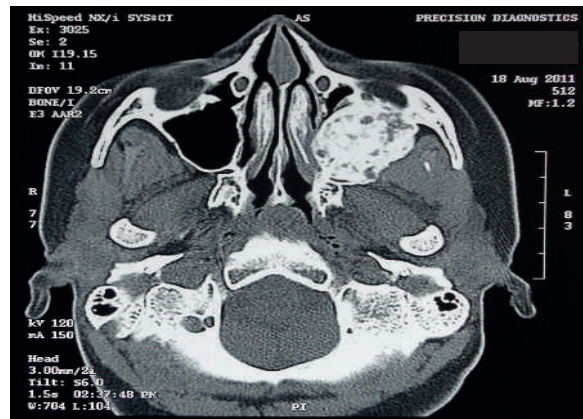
CT scan showing diffuse radio opaque areas within the lesion after intralesional corticosteroid injection
